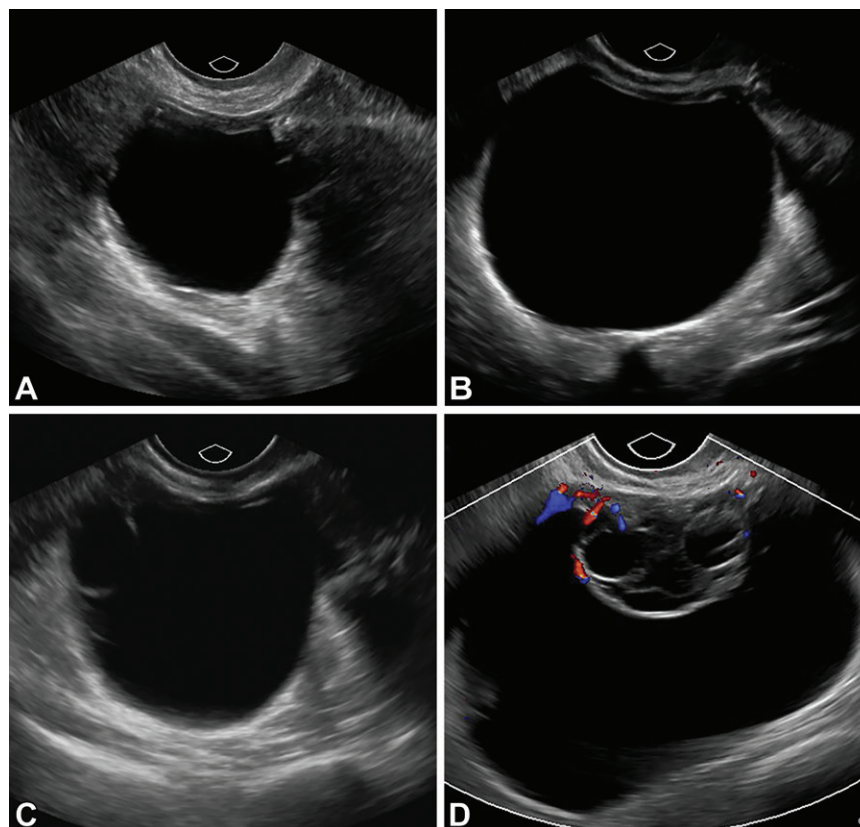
Importance of a high-quality US examination in the evaluation of ovarian cysts. (A) Initial US image shows a simple ovarian cyst measuring 3.2 cm in a postmenopausal woman. No cine clip was included in the examination. This lesion would have been classified as O-RADS 2. (B) Follow-up US image obtained 5 years later shows a larger simple cyst measuring 7.4 cm. (C) Static gray-scale US image from the cine clip of this examination shows a thin septum, which was not reported. (D) Final follow-up US image obtained 8 years after the initial study shows enlargement of the cyst with increased complexity, more septa, and color Doppler flow that is consistent with an O-RADS 3 lesion. This case highlights the importance of a quality US examination with review of cine clips, as the lesion would have been categorized as O-RADS 3 at the 5-year follow-up and potentially may have been more complex than depicted on the static images from the initial US study. The patient has not had additional follow-up and declined surgery for this presumed epithelial neoplasm.
